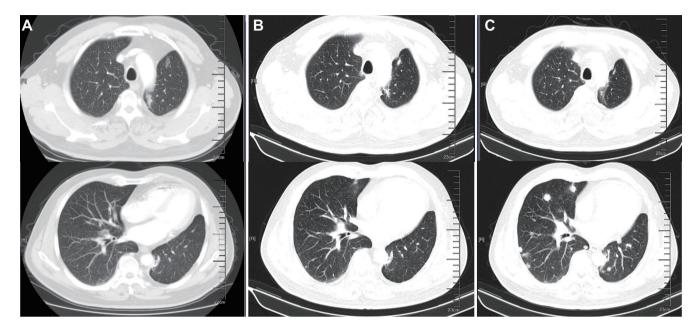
CT scans before and after therapy in a case of *ERC1-RET* fusion. (A) CT scans before Cabozantinib. (B) CT scans after 4 months of treatment with Cabozantinib. (C) CT scans after 10 months of treatment with Cabozantinib. CT, computed tomography.
